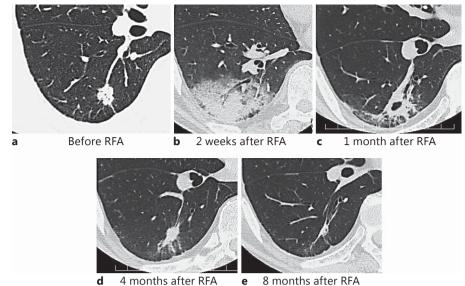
Serial CT findings before and after CT-guided bronchoscopy cooled RFA in case 20. RFA was performed for a mass in the right B6 area (adenocarcinoma, a). The patient presented with right chest pain and fever after the treatment, and chest CT findings revealed consolidation in the right lower lung field (b). Then, the shadow decreased and changed to a scarring shadow without any specific treatments (c-e).
